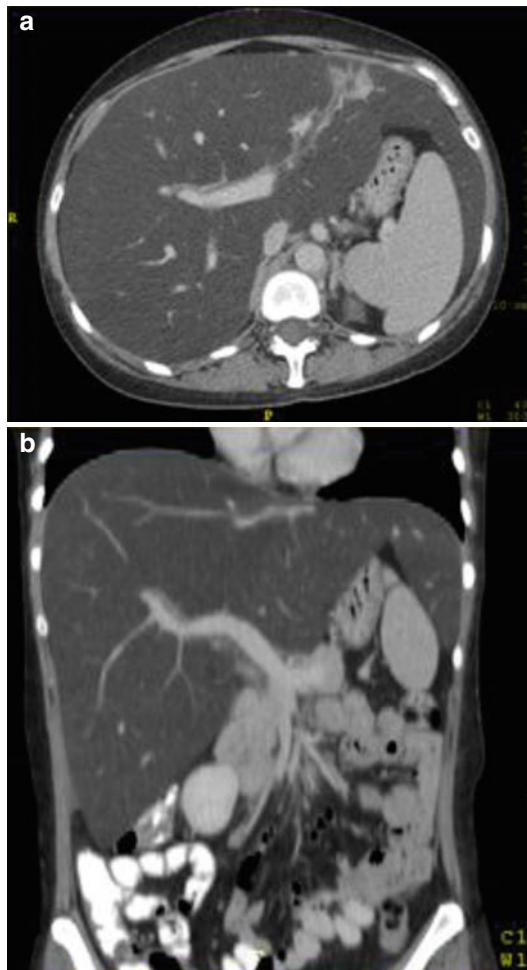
(a, b) Hepatic steatosis post-chemotherapy, axial (a) and coronal (b) post-contrast CT images showing marked hypodensity of the liver parenchyma evident even after contrast injection
